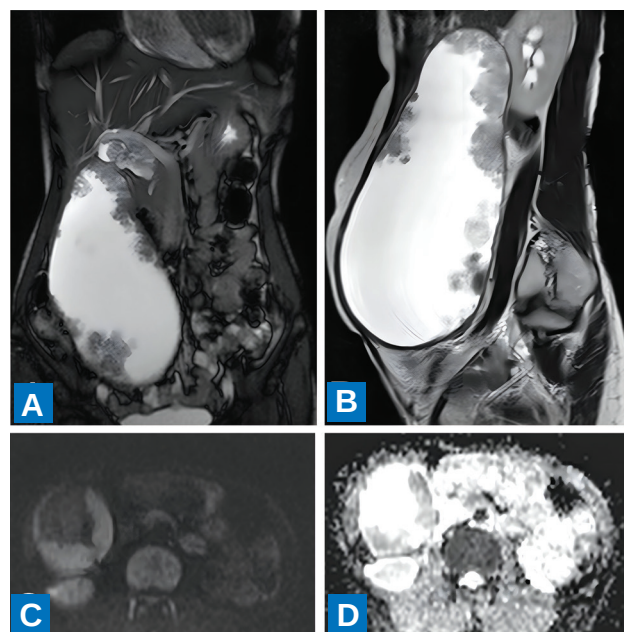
MRI images. (A) Coronal; (B) sagittal T2 weighted images showing hypointense lesion in the gall bladder; (C) diffusion-weighted imaging (DWI); (D) apparent diffusion coefficient (ADC) imaging, demonstrating the lesion arising from the walls of gallbladder predominantly in the neck and body region with restricted diffusion on DWI.
